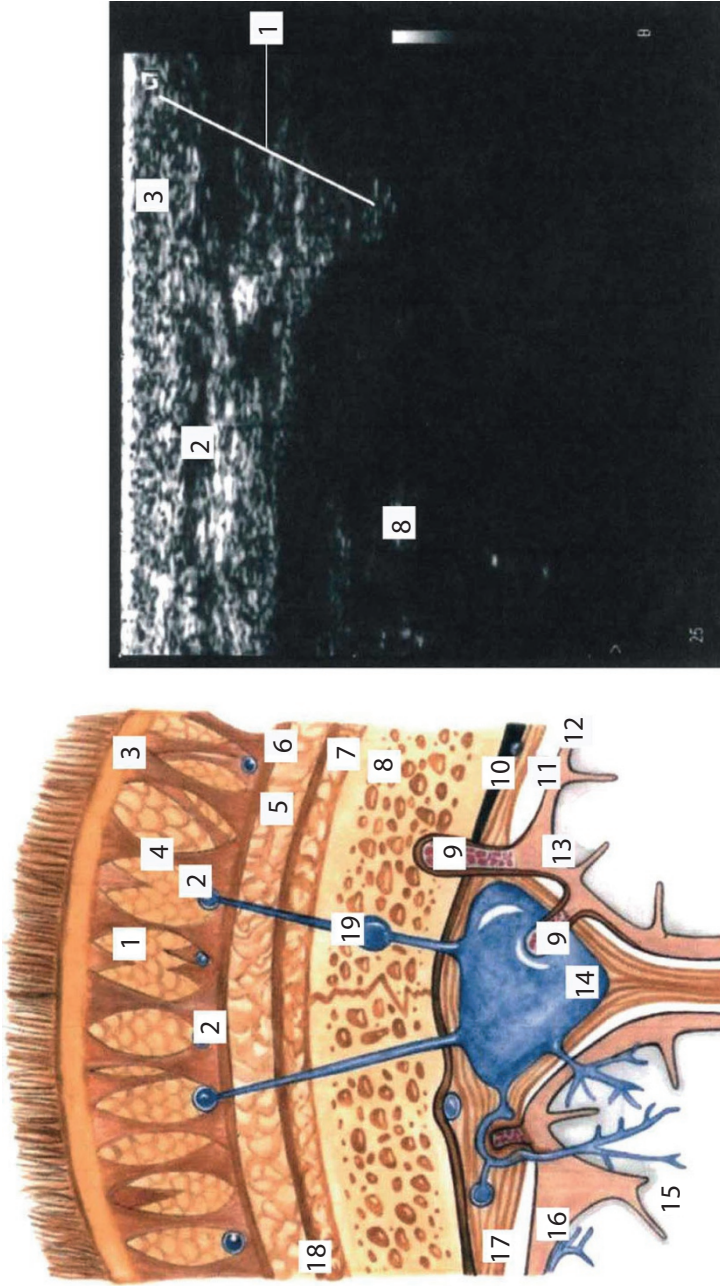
Comparative ultrasonic topographical anatomy of the head.
